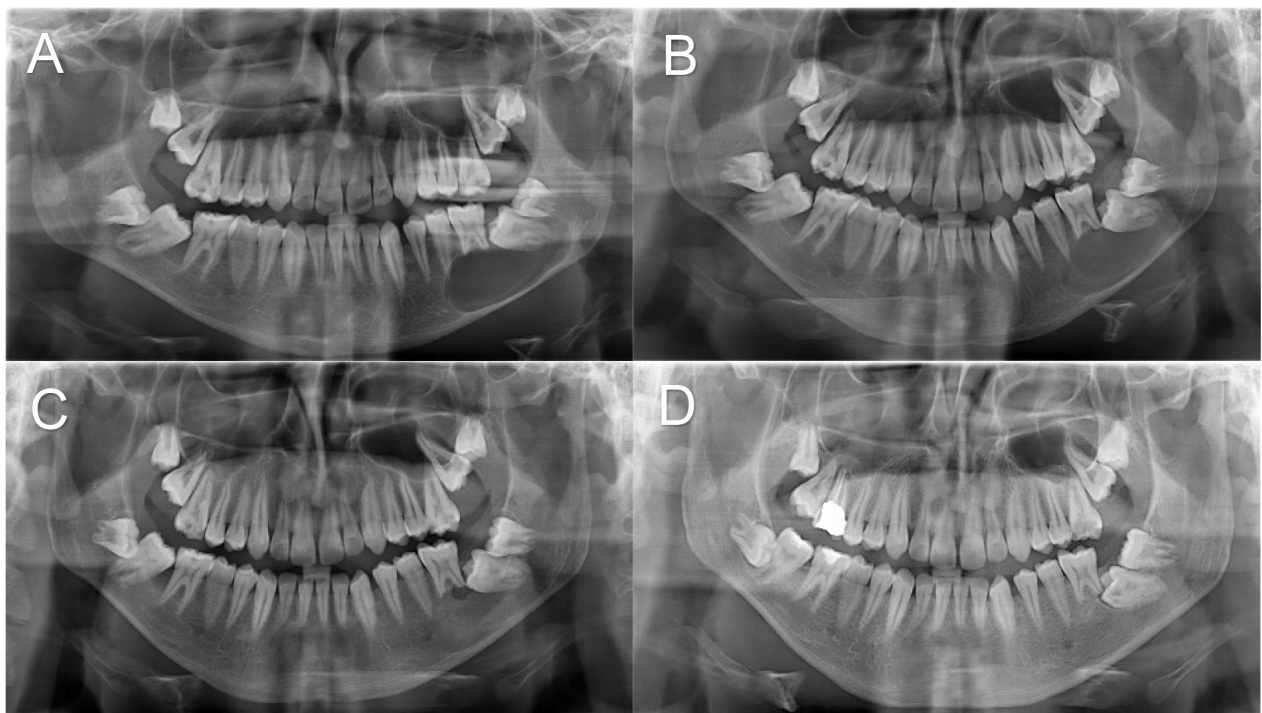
Case 3: panoramic radiographic findings during treatment. (A) Pre-operative. (B) Post-operative 3-month follow-up. (C) Post-operative 6-month follow-up. (D) Post-operative 12-month follow-up.
